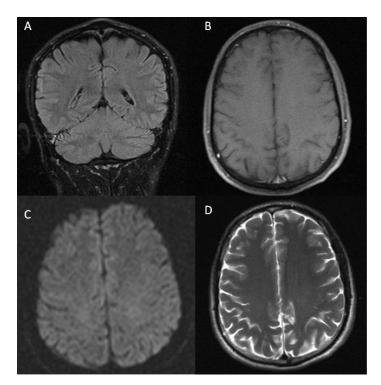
Control MRI performed forty days later: FLAIR (A), T1 (B), DWI (C) and T2 (D) sequences showed complete resolution of both dentate and diencephalic hyperintensities and also ring enhancing lesions.
